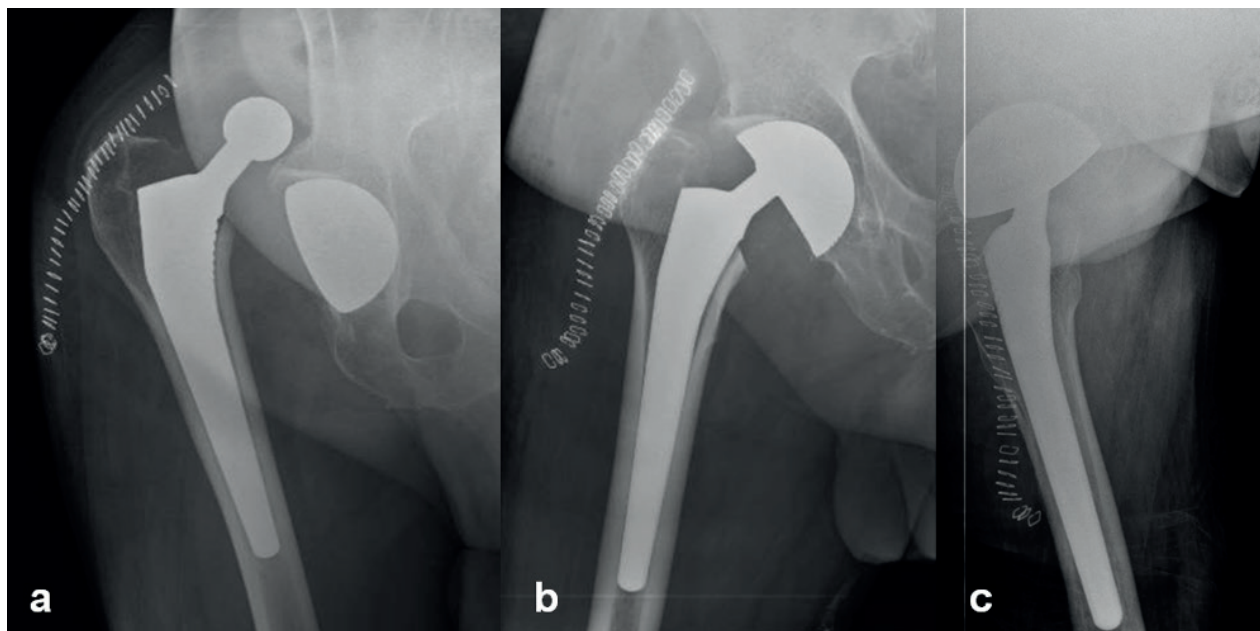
a) Intraprostatic dislocation occurred 12 days after the surgery; b-c) Post-reduction x-ray
